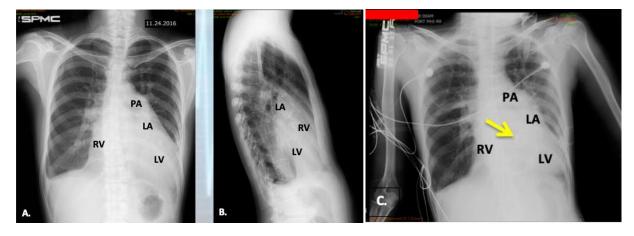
Chest radiography. (Preoperative) A. Postero-anterior view showing biventricular cardiomegaly and left atrial enlargement with blunting of bilateral costophrenic sulci. B. Lateral view showing obliteration of retrosternal and retrocardiac space. (Postoperative) C. AP view revealed biventricular and left atrial cardiomegaly that are regressing in size and bilateral minimal pleural effusion. Mechanical mitral valve (yellow arrow) can also be identified. PA: pulmonary artery; LA: left atrium; LV: left ventricle; RV: right ventricle.
